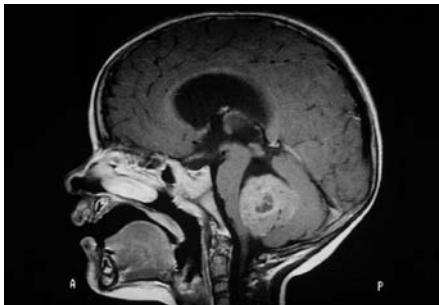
Sagittal, gadolinium-enhanced, T1-weighted MRI of an anaplastic ependymoma of the fourth ventricle.
